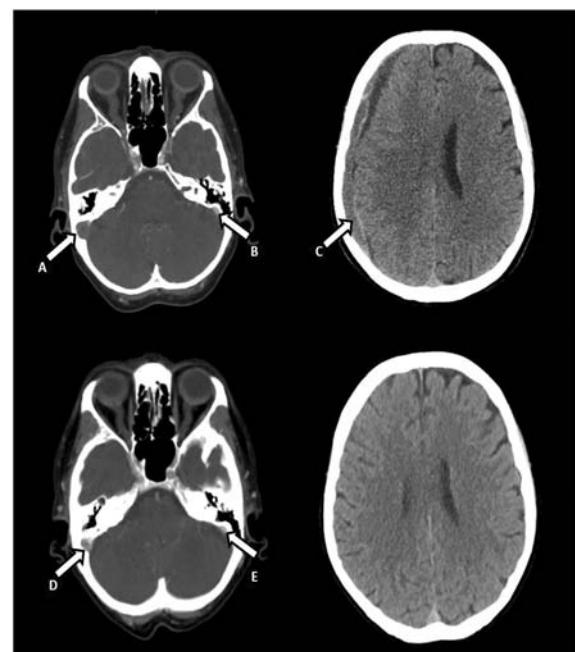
Venous sinus thrombosis shown on CT Venogram as filling defect in the right sigmoid sinus (A and D). Contrast can be seen flowing in left sigmoid sinus (B and E). Acute on chronic subdural haematoma (C) shown on CT scan of brain, this resolved 3 months later.
